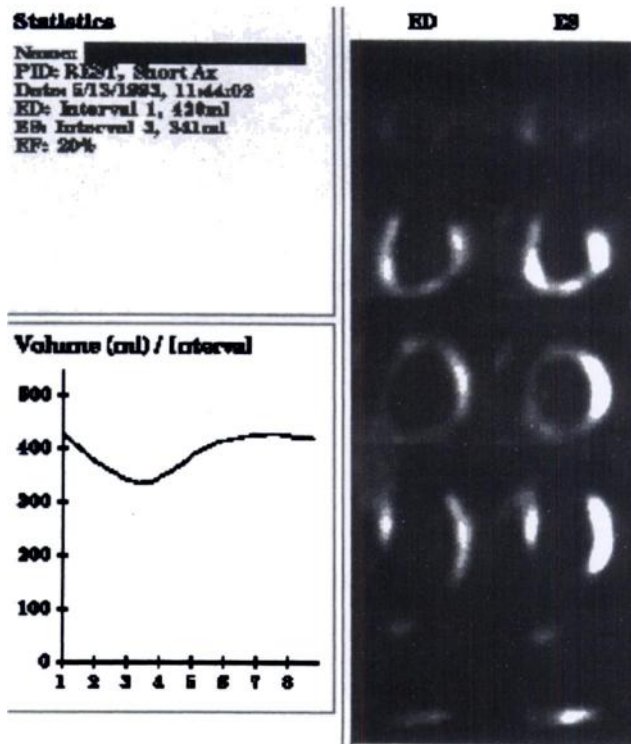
Quantitative gated SPECT algorithm results for the patient in Figure 8. Global LVEF (20%) and dynamic range of the endocardial time-volume curve are lower compared to the normal patient in Figure 7.
